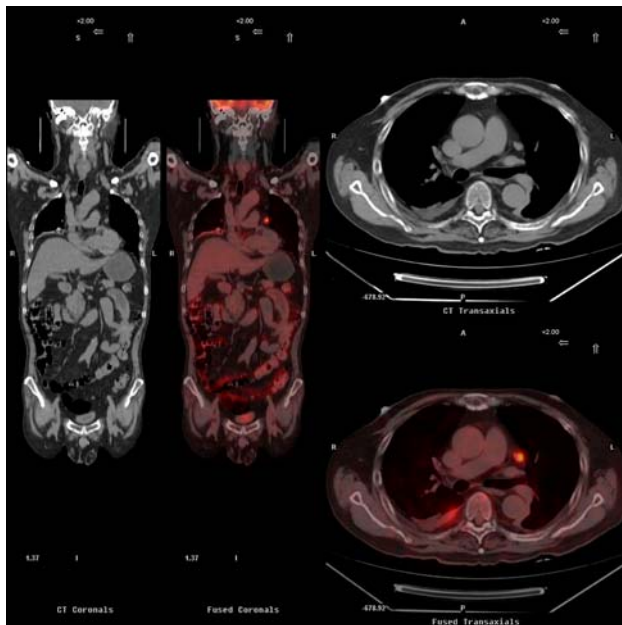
Integrated whole-body ^{18}F -FDG PET/CT case study of one patient. Coronal images (*left*) and transaxial images of mediastinum window (*right*), CT images and PET/CT fused images. The study revealed a mass with intense FDG uptake beside the left pulmonary artery in the mediastinum. The diameter of the mass was 1.1 cm, and SUV_{max} was 9.4. It also demonstrated a high-FDG uptake of pneumonia in the lower lobe of the right lung, the SUV_{max} was 8.2
